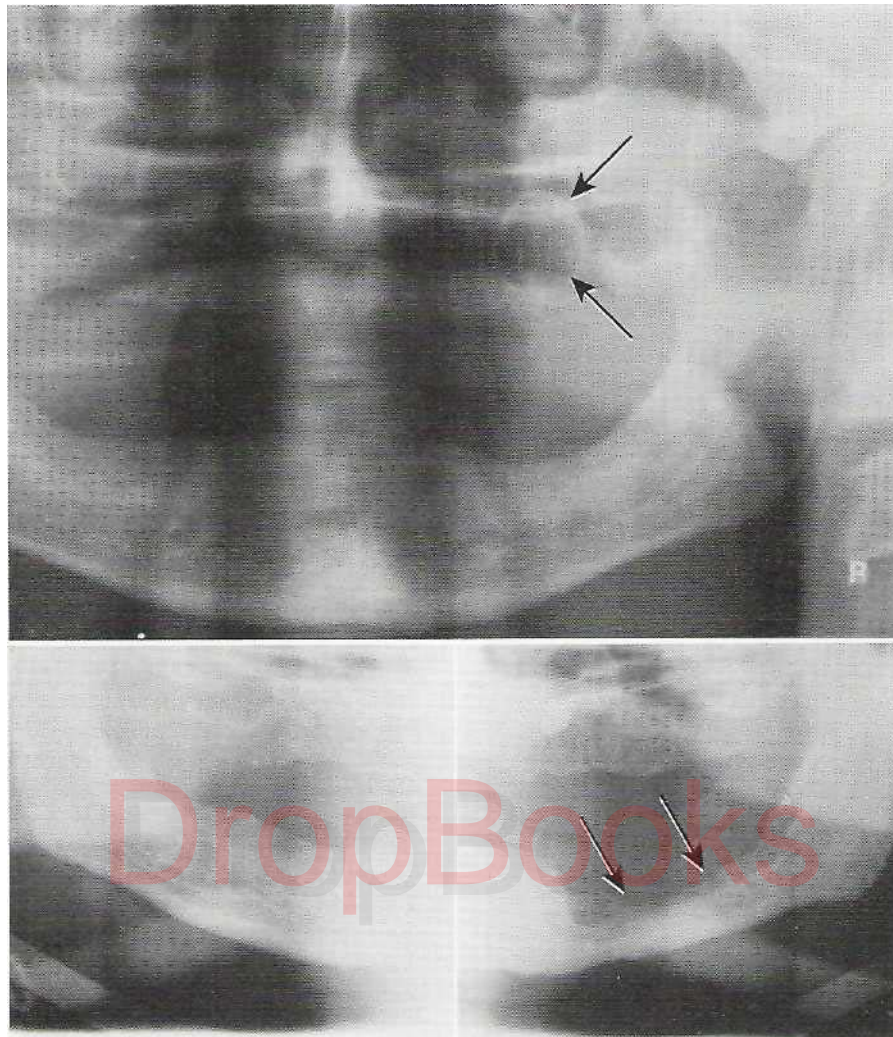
A, Radiographic appearance of cyst (arrows). Note peripheral condensing osteitis around radiolucent center. B, Radiographic appearance of bone destruction by malignancy (arrows). Squamous cell carcinoma has eroded into mandible. Note ragged appearance
